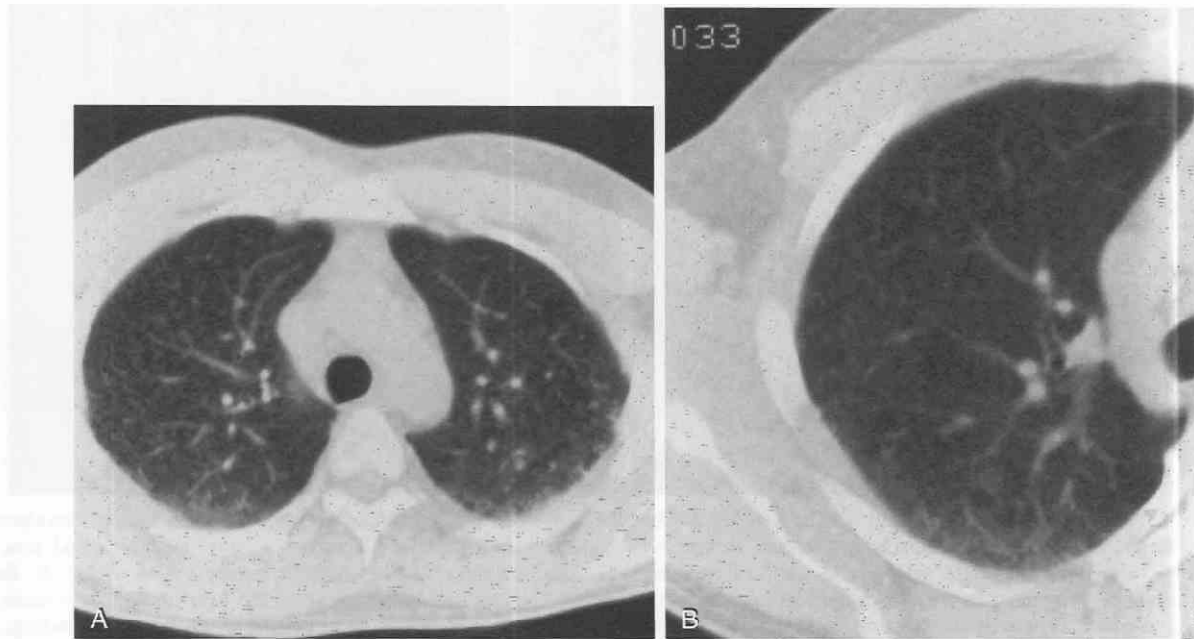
A and B, CT findings in a patient with silicosis. The diffuse profusion of micronodules is caused by silicosis. (From Kuhlman JE: CT of diffuse lung disease. *Appl Radiol* 20:17-21, 1991.)
